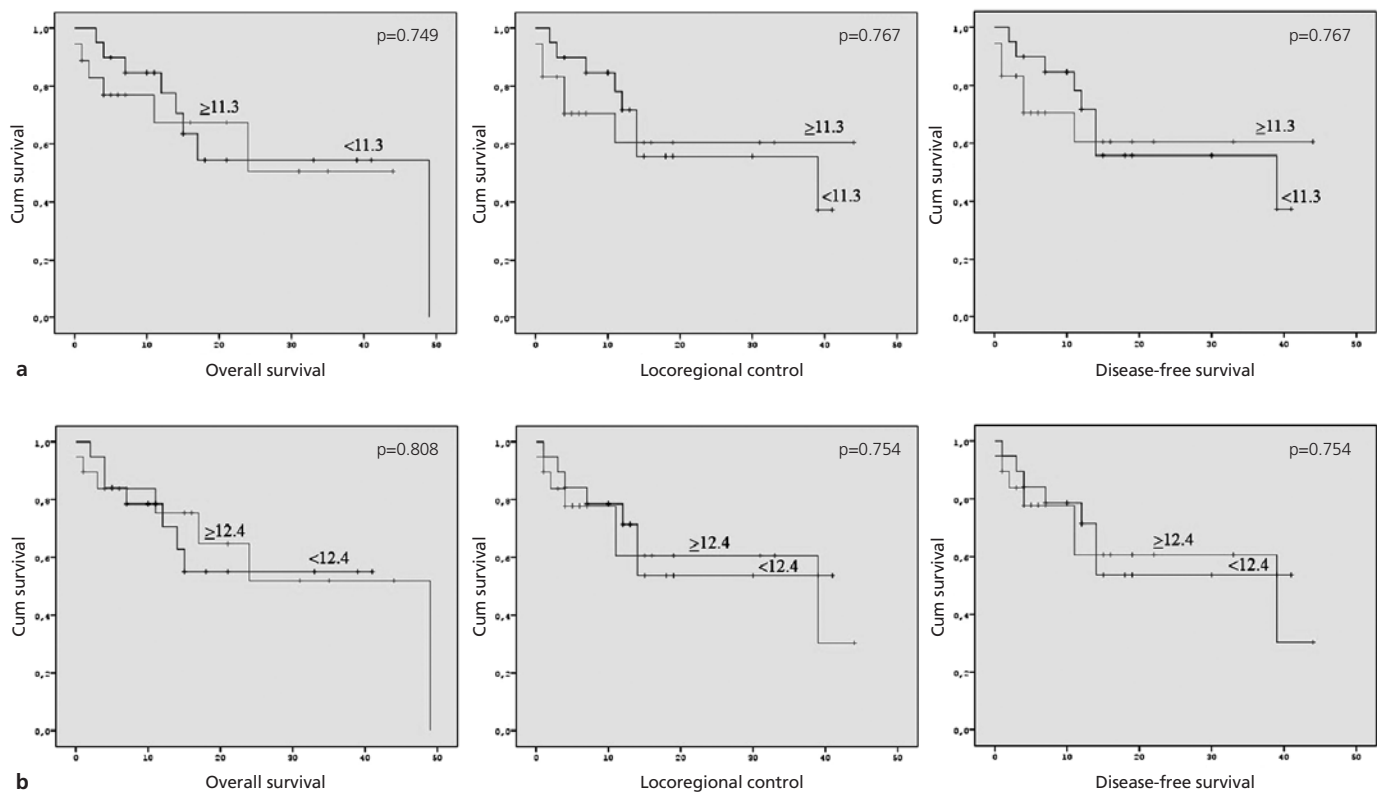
The comparison of 2-year OS, LRC and DFS according to pretreatment (a) SUV, (b) SUV_{max}, (c) SUV_{mean}, (d) MTV, (e) MTI_{max}, and (f) MTI_{mean} values in patients with advanced-stage laryngeal cancer. [Continued on next page]
